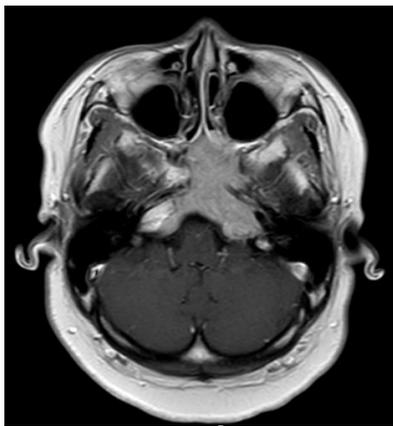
MRI of the brain revealed a 4.7 x 5.5 x 3 cm intrasellar mass extending into the sphenoid bones and affecting the left internal carotid artery
